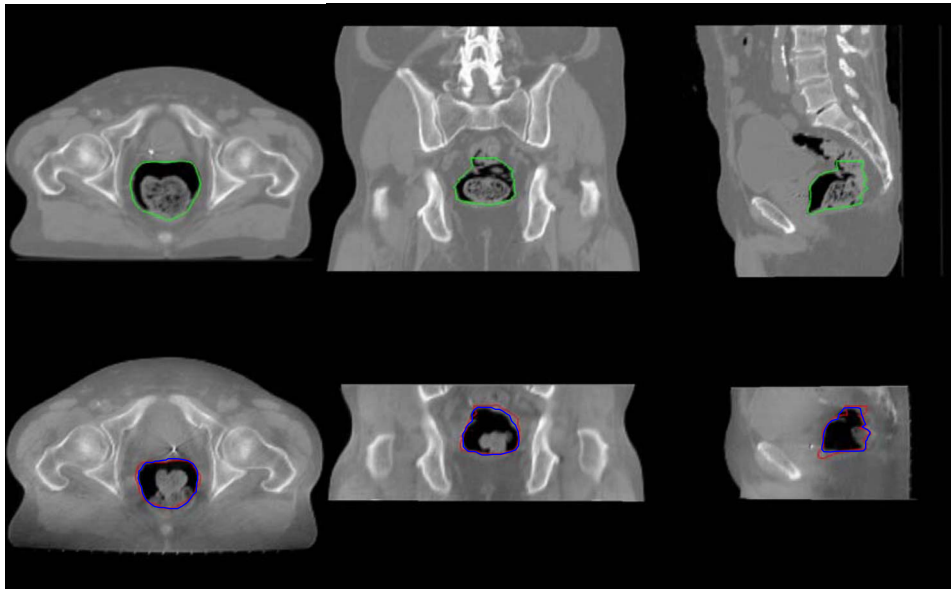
3D contour mapping for the rectum of a man with prostate cancer. The top row is the three transactions in the planning CT image, the bottom row is corresponding transactions in the CBCT image. The left column is the axial plane, the middle column is the coronal plane, and the right column is the sagittal plane.
